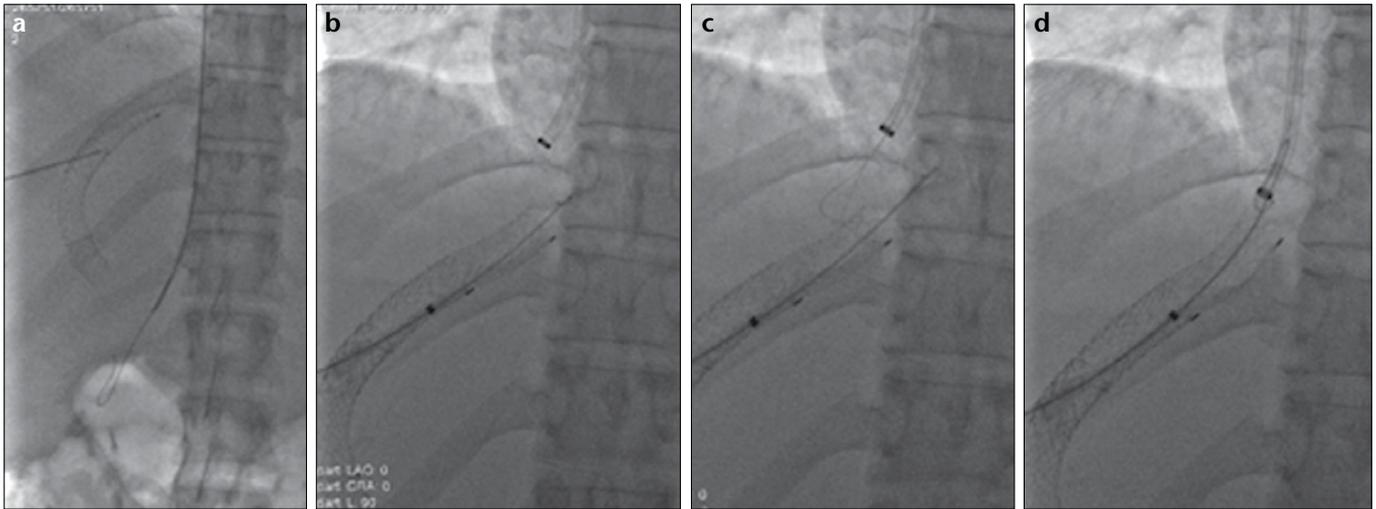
a–d. Fluoroscopic images of a 36-year-old patient with Budd-Chiari syndrome who received TIPS placement 14 months earlier for refractory ascites. Doppler US showed evidence of stent occlusion with subsequent, failure of standard transvenous catheterization of the occluded stent, and failure of catheterization of the mouth of the stent with the Colapinto needle, where a combined transhepatic and transvenous approach was used. Percutaneous puncture of the stent (a) was performed with a 20-gauge needle advanced under US and fluoroscopic guidance. Percutaneous catheterization of the stent, where a guidewire is advanced through the stent over a 6F sheath is seen (b). A snare (c) is advanced from the jugular sheath. The guidewire (d) is captured with the snare.
